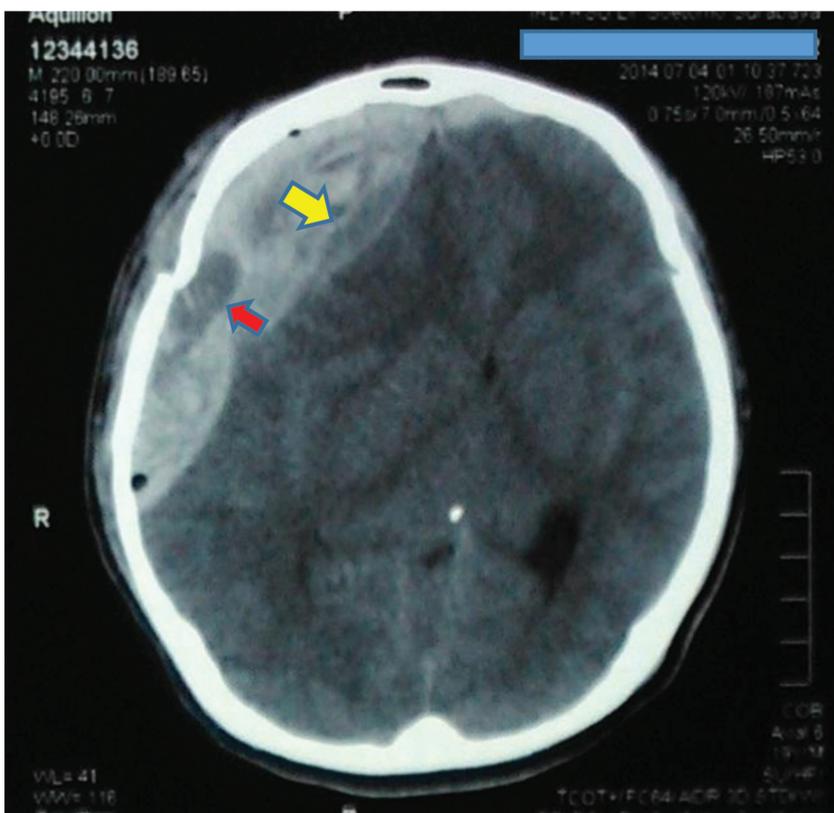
An axial view of non-contrast head CT. Note the hypodense lesion within the hyperdense. A red arrow indicates the active bleeding from the fracture site. The yellow arrow indicates the active bleeding from meningeal branch vessels
